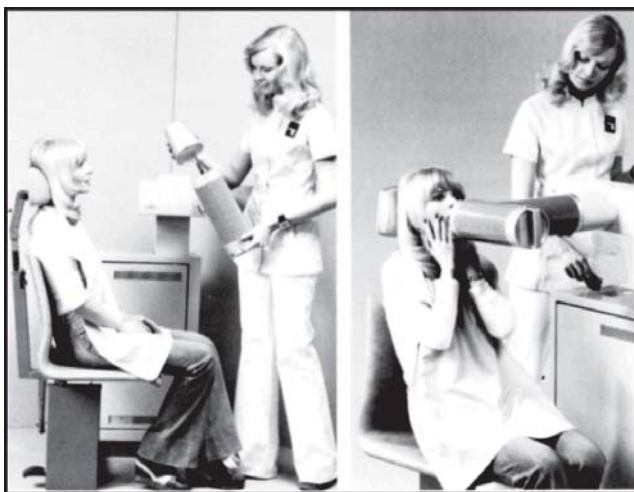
The status X-ray intraoral X-ray source machine
